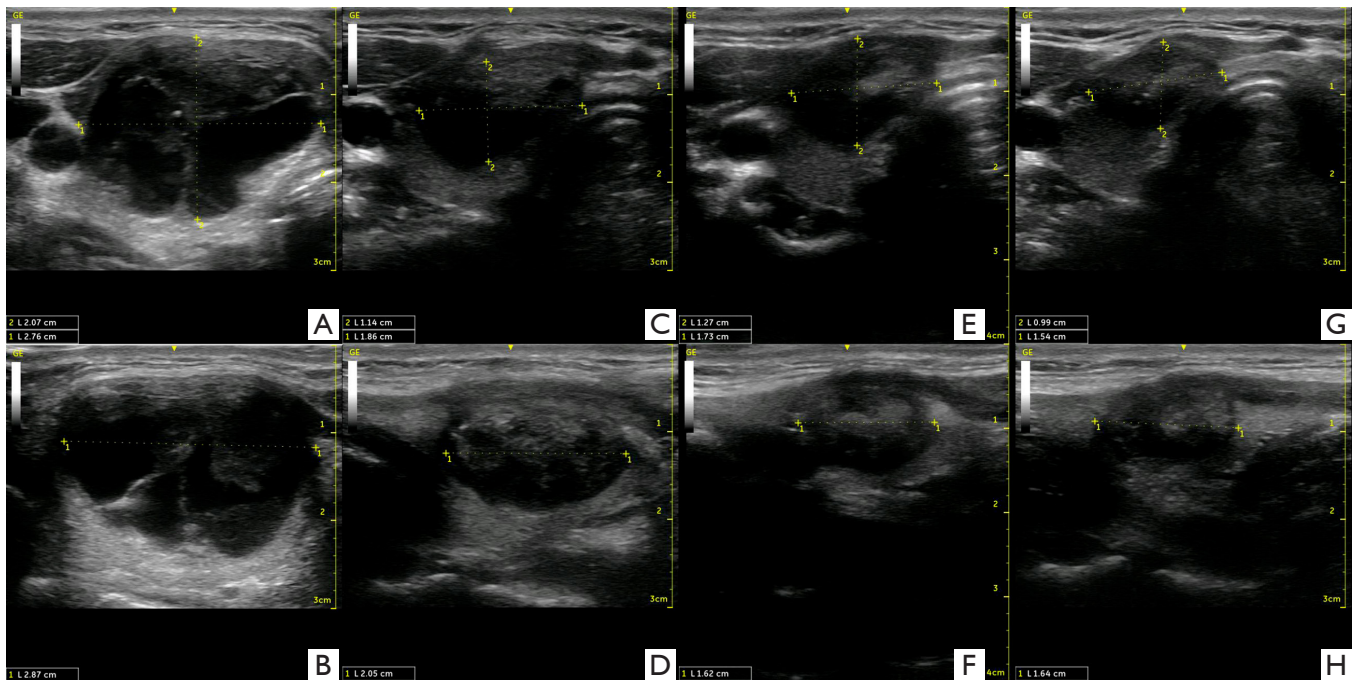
Ultrasound evolution of a right lobe mixed benign nodule. (A,B) Initial volume is 8.5 cc, (C,D) after one month the volume is 2.2 cc, (E,F) after three months the volume is 1.85 cc, (G,H) after 12 months the volume is 1.3 cc. The VRR 84.7% after 12 months. VRR, volume reduction ratio.
